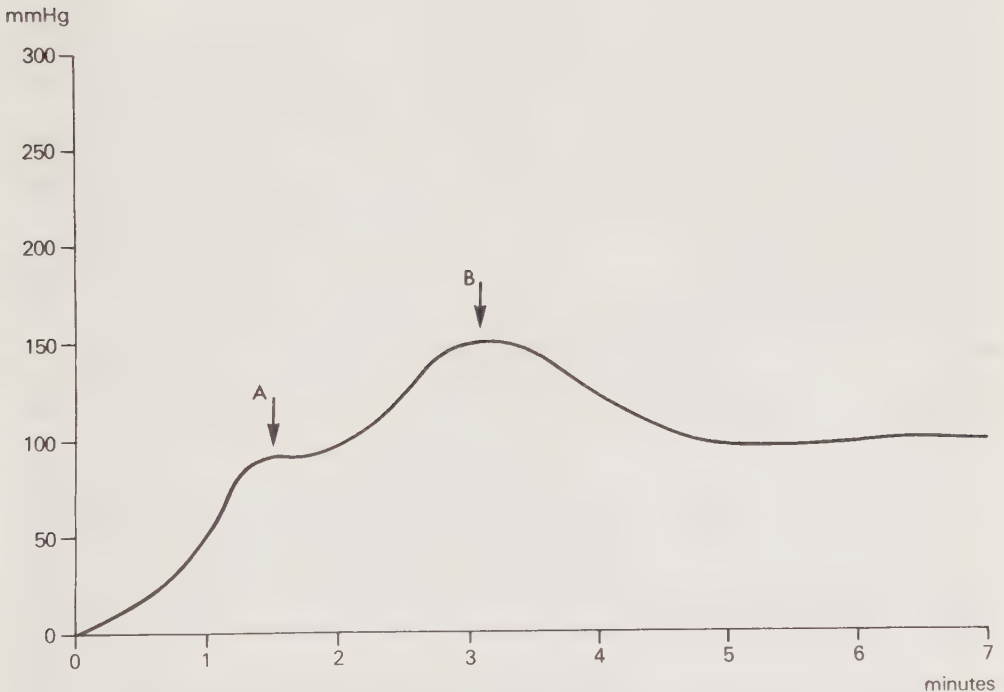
Typical intraglandular pressure development during retrograde infusion of lipid-soluble radiographic contrast medium. The arrows indicate where infusion was stopped to achieve ductal and slight parenchymal filling (A) and heavy parenchymal filling (B), respectively.
